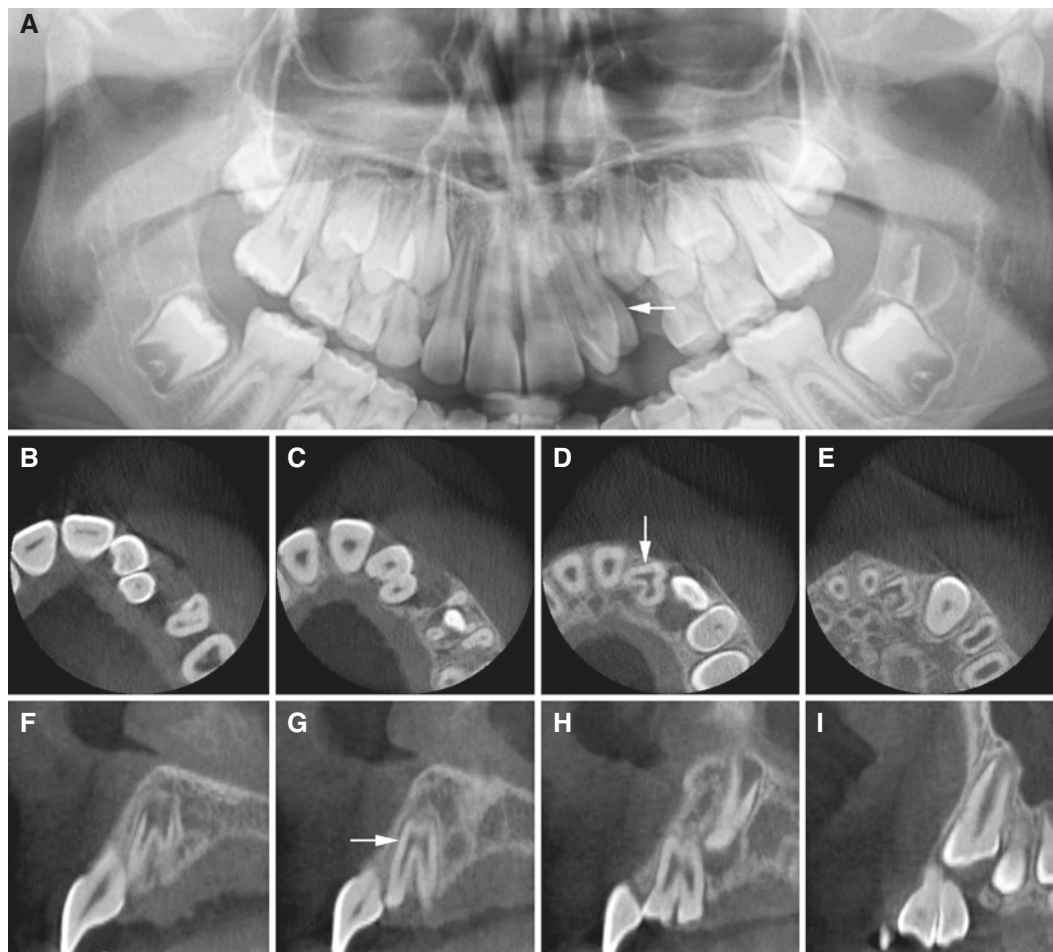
“Double tooth,” maxilla; 9-year-old female. (A) Panoramic view suggests double lateral incisor (*arrow*). (B, C, D, E) Axial and (F, G, H, I) oblique sagittal CBCT images probably show gemination and not fusion of incisors (*arrow*)
